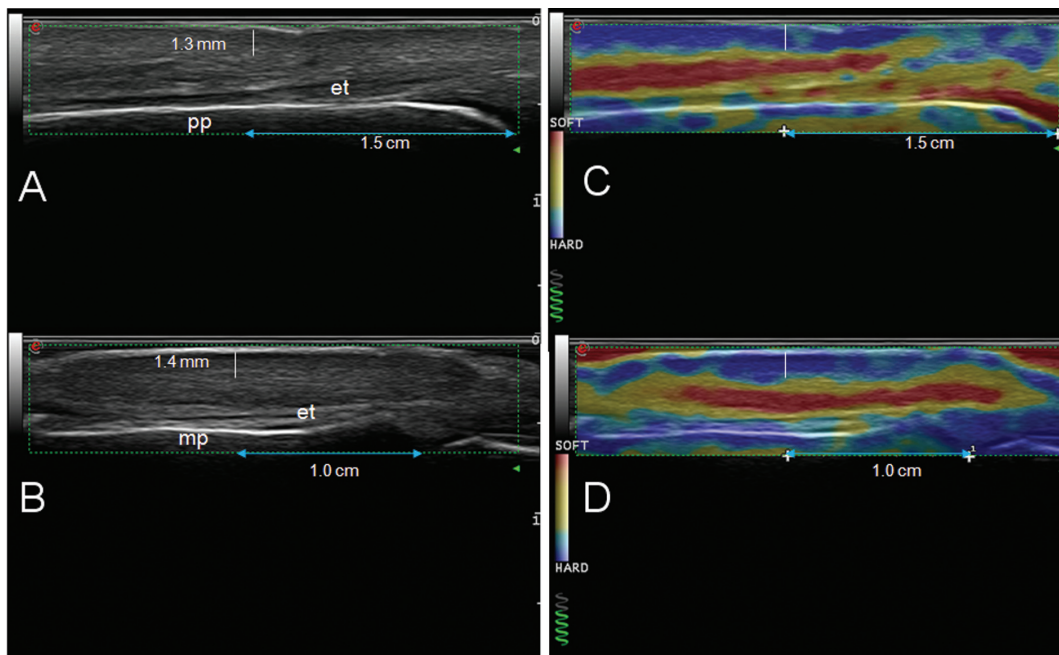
Dermal thickness measurements in grey-scale and with elastosonography. Longitudinal dorsal views of the proximal and middle phalanx in grey-scale (A-B) and the corresponding elastograms (C-D), being the vertical white lines representative of the measurements of the dermal thickness, taken at 1.5 cm and 1 cm distally from the bases of the proximal and middle phalanx, respectively. pp: proximal phalanx; mp: middle phalanx; et: extensor tendon.
